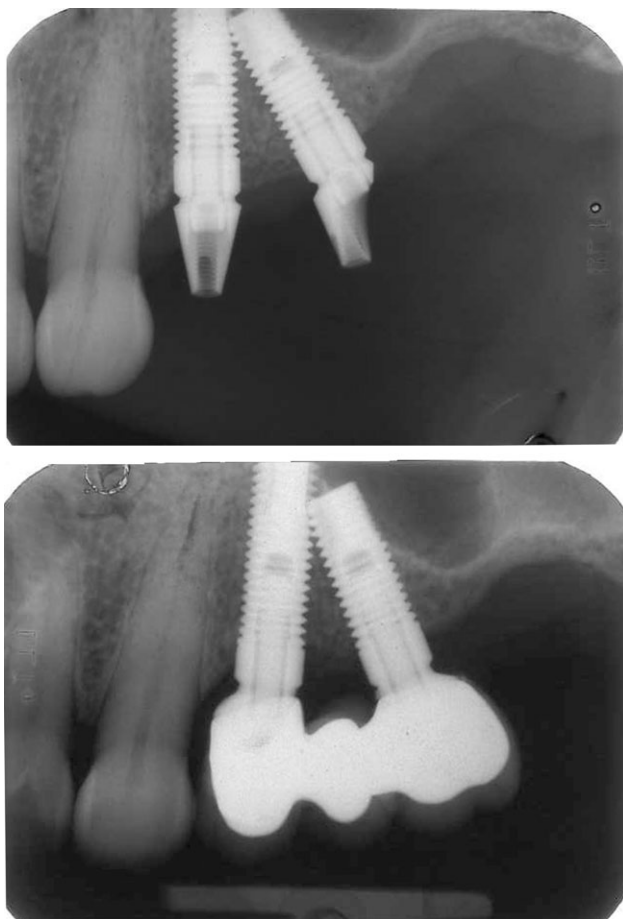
X-rays at abutment connection and at 1 year of loading. Angled abutments were used for this patient.
